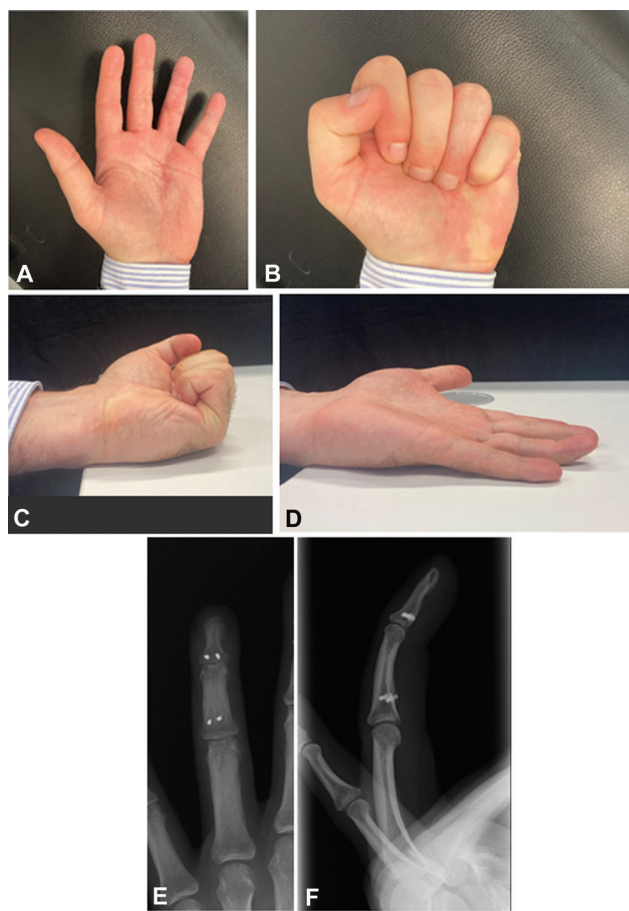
(A–D) Clinical outcome after completion of 12 months of follow-up. (E, F) X-ray outcome at completion of 12 months of follow-up.
